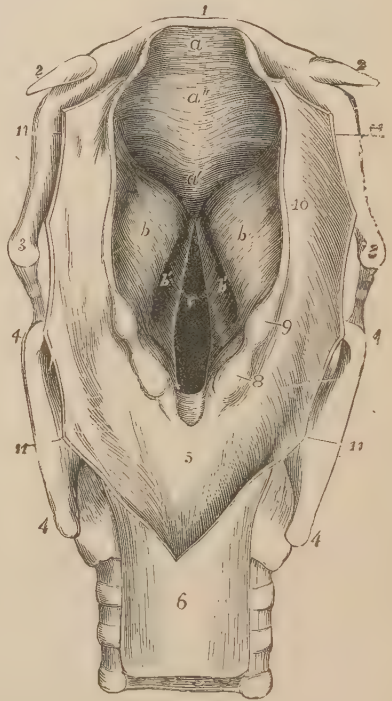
PERSPECTIVE VIEW OF THE PHARYNGEAL OPENING INTO THE LARYNX FROM ABOVE AND BEHIND. (Allen Thomson.)
